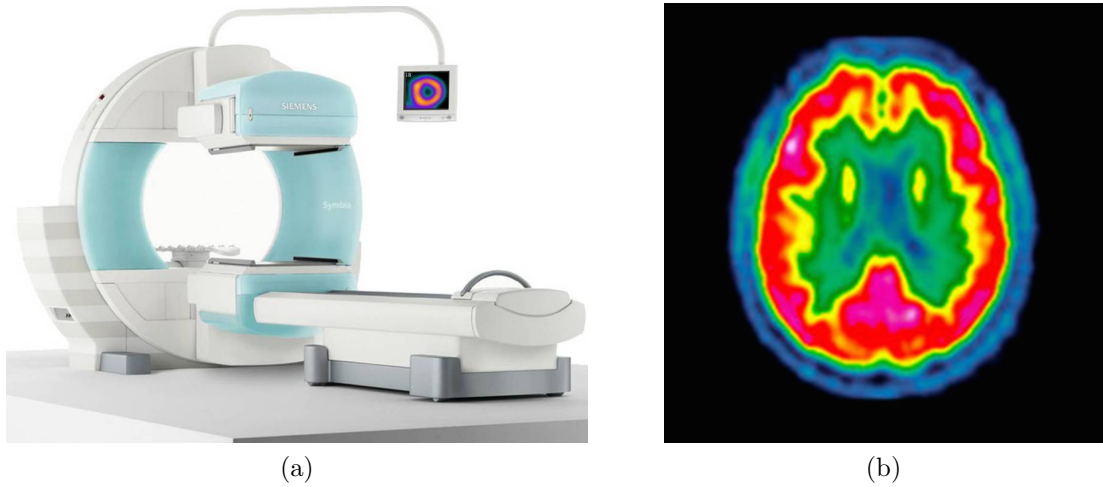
(a) SPECT scanner, Siemens Symbia<sup>TM</sup> S. (b) SPECT image showing normal brain activity<sup>3</sup>.
